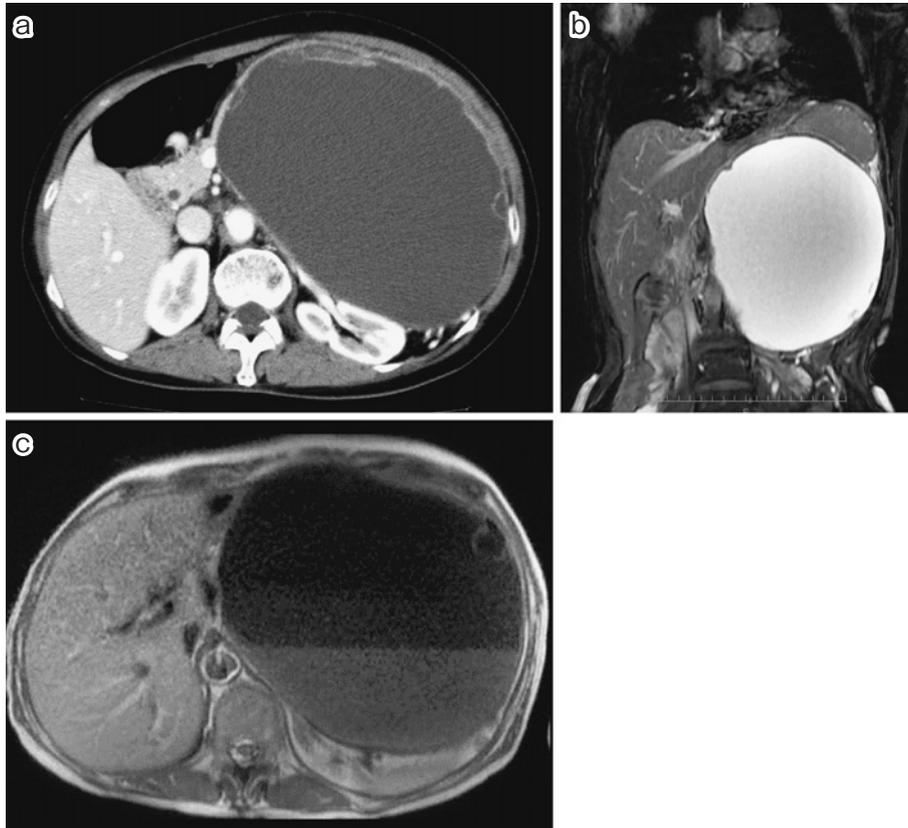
Abdominal computed tomography (CT) showed a large cystic mass (diameter, >20 cm) in the left upper abdominal quadrant and a slightly enhanced cystic wall (a). Magnetic resonance imaging (MRI) findings showed no mural nodule in the cyst; however, peripheral septum was suspected and fluid-fluid level was observed (b, c).
